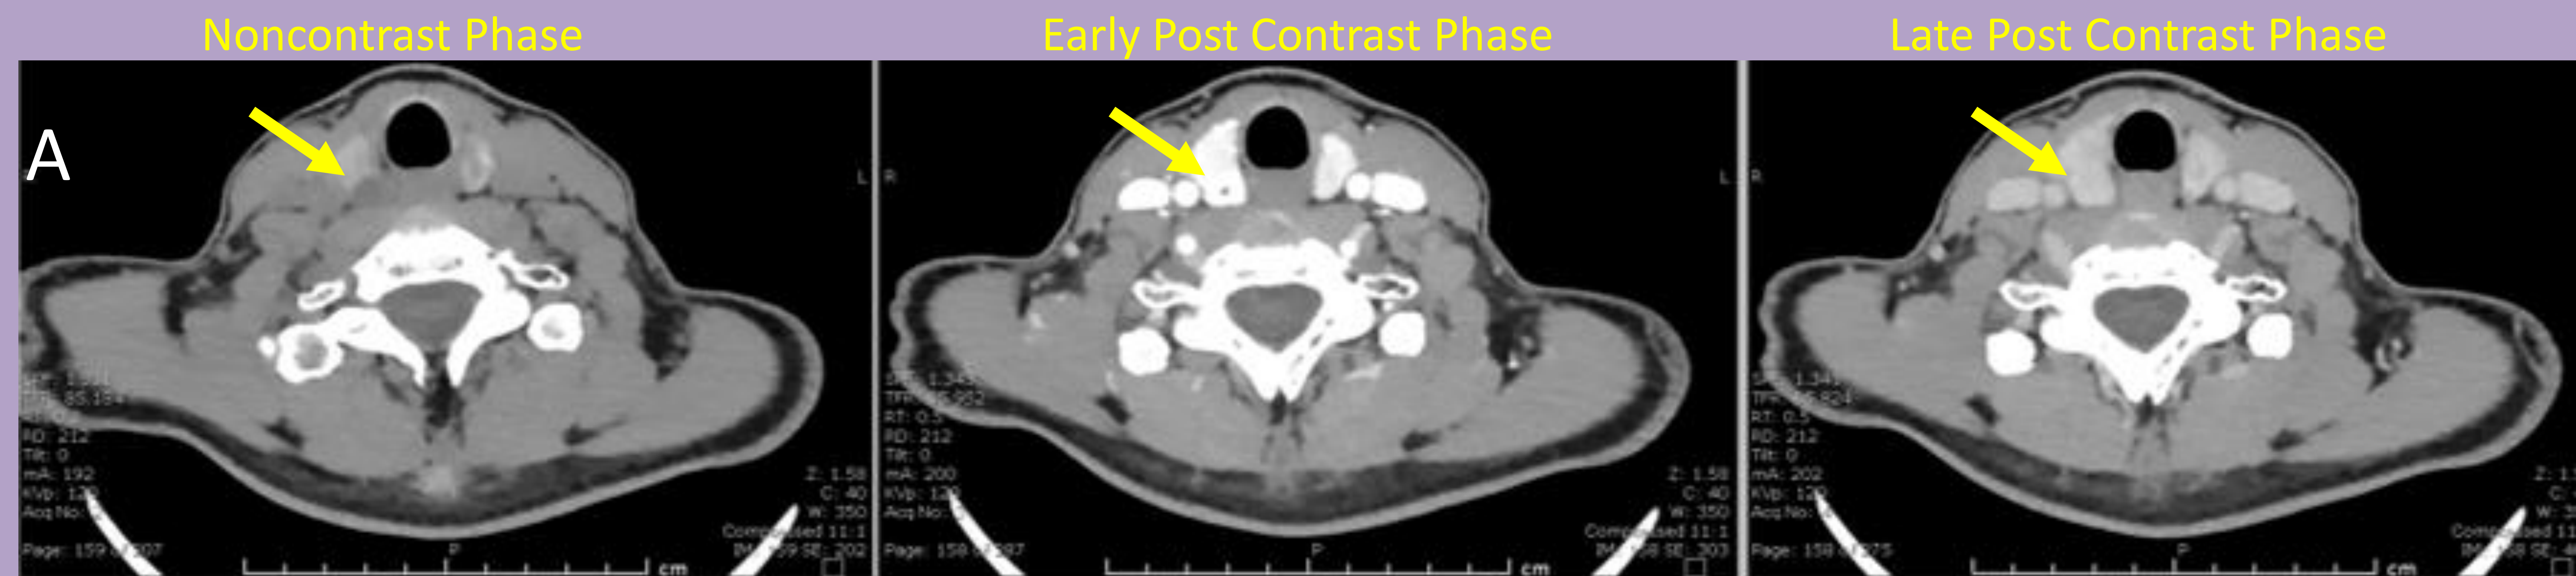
A. 4D Parathyroid CT showing right sided mass with characteristic appearance and enhancement of parathyroid adenoma. B. US revealing hypodense mass posterior to right lobe of thyroid.
